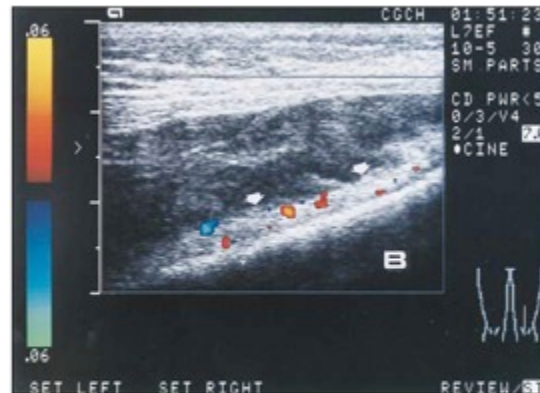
Initial CDUS image (case 10) demonstrates thickened periosteum (arrows) with high duplex ultrasonographic vascularity and correlates with high serum CRP levels. This CDUS feature indicates advanced osteomyelitis. B, Bone.
